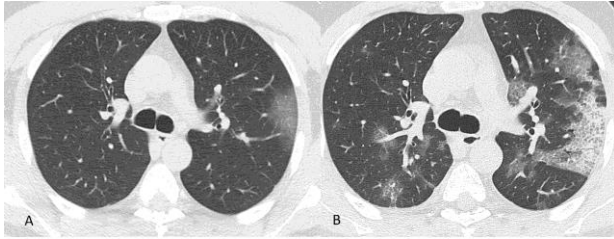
A 38-year-old male patient who presented with cough and malaise had peripheral and central GGO density on the CT examination performed on the day of onset of symptoms (A). The CT of the same patient performed on day 11 showed an increase in the GGO density, crazy-paving pattern, and consolidation visualized in the left lung, as well as central, peribronchovascular, peripheral GGO density and subpleural fibrotic bands in the right lung (B).
